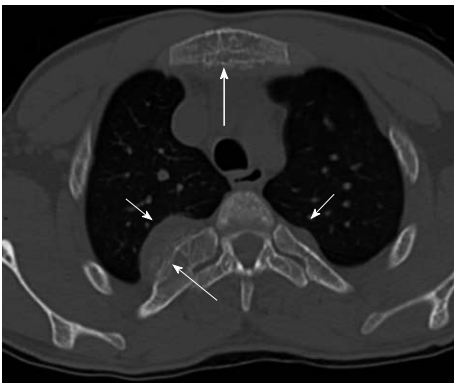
Pre-operative "bone window" computed tomography scan of the chest without contrast media shows large bilateral, well circumscribed lobulated soft tissue masses that cause widening of the ribs (short arrows) and periosteal reaction, without interruption of cortical bone (thin long arrow). Coexisting involvement of the sternum body (thick long arrow).
